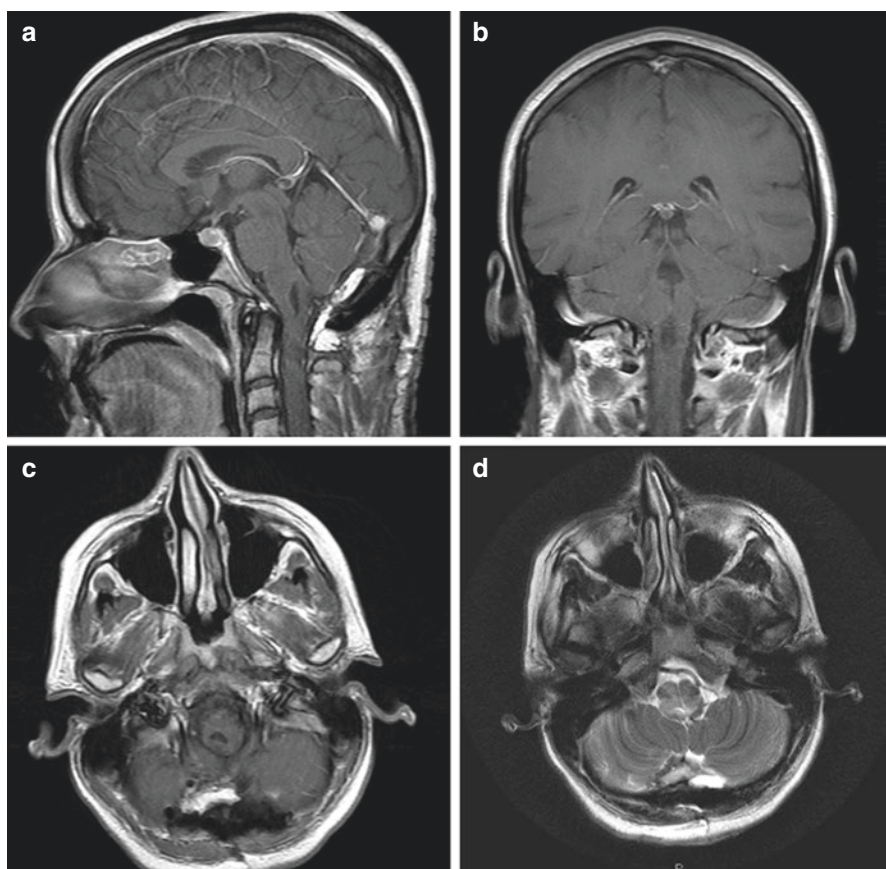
Postoperative MRI of brain of Patient 1 [57]. (a) Post-contrast sagittal T1-weighted MRI showing cyst collapse after nodule resection. Note the fat graft dorsal to the dura to avoid CSF leak or pseudomeningocele formation. (b) Post-contrast coronal T1-weighted MRI showing cyst collapse after nodule resection. (c) Post-contrast axial T1-weighted MRI showing cyst collapse after nodule resection. Note the fat graft dorsal to the dura to avoid CSF leak or pseudomeningocele formation. (d) T2-weighted axial MRI showing cyst collapse after nodule resection
